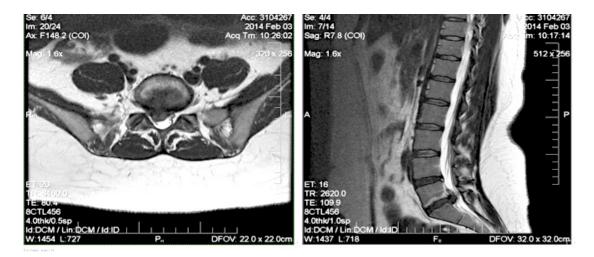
Pre discectomy T2 weighted MRI showing L5/S1 disc protrusion and minor L5 inferioir end plate changes.
